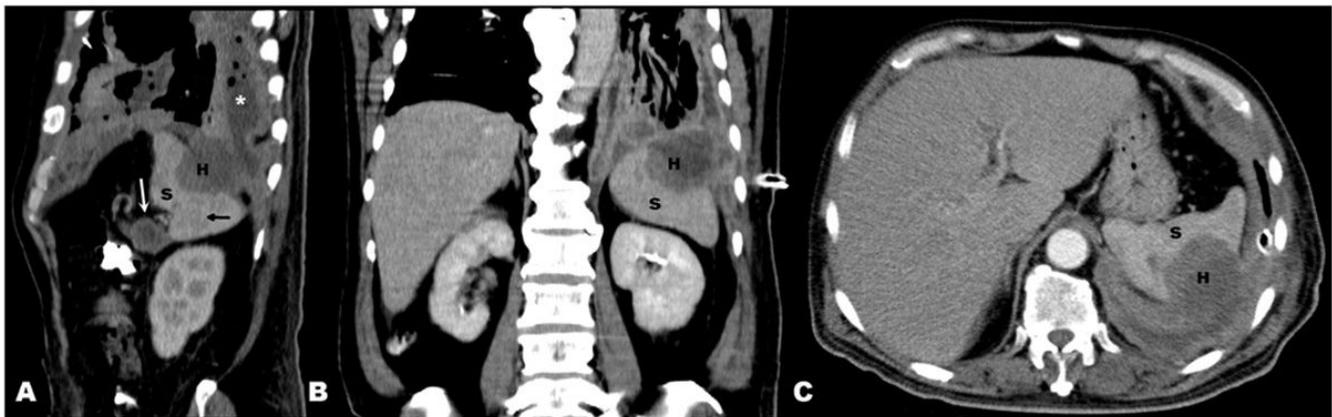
Thoracoabdominal sagittal (A), coronal (B), axial (C) CT; massive hemothorax (*) in the left pleural cavity, contour irregularity on the diaphragm surface and the appearance of diaphragm hematoma (H) are observed. Additionally, pancreas mass (black arrow) and adjacent spleen (S) metastasis (white arrow) are seen.
